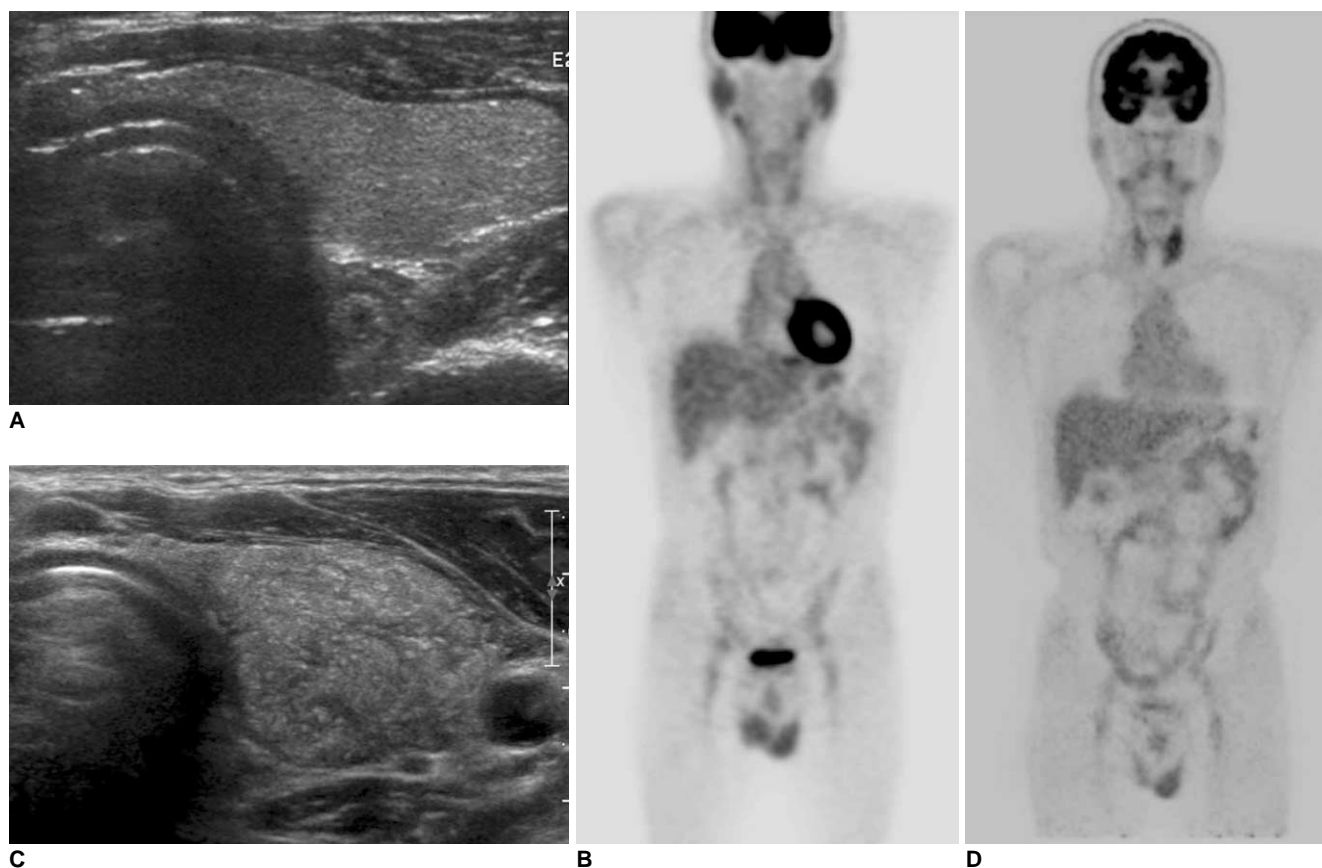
Diffuse sclerosing variant of papillary thyroid carcinoma in 48-year-old man. A, B. Initial thyroid ultrasonography (A) and PET scan (B) have normal appearance. C, D. Second-round screening examination was performed two years later. Ultrasonography (C) shows diffuse enlargement of left thyroid gland with heterogeneous echogenicity and formation of suspicious mass. It is regarded as pseudo-mass by heterogeneous parenchyma of left thyroid. PET scan (D) shows increased FDG uptake in both thyroid glands, especially in left lobe. These findings are regarded as benign thyroid disease and call for recommended follow-up examination.
